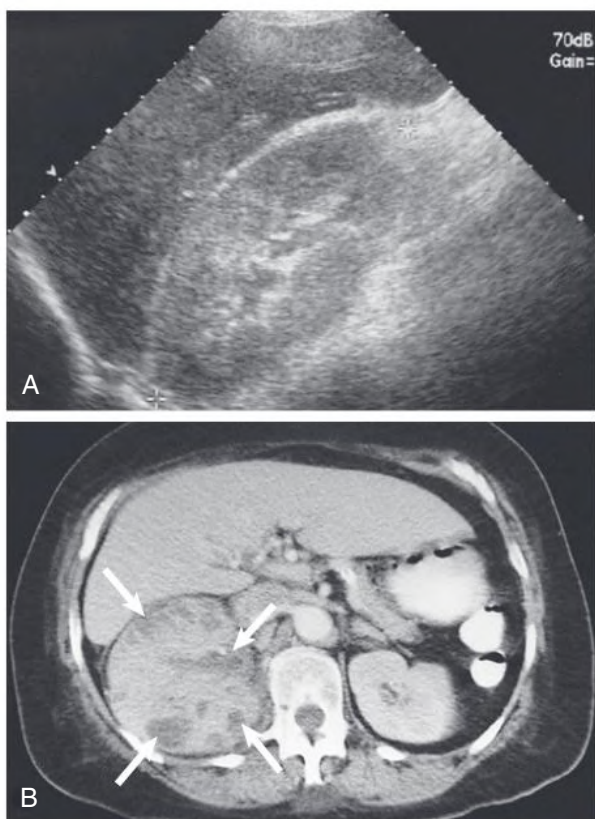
Acute Pyelonephritis. (A) Ultrasound image demonstrates an enlarged echogenic kidney. Bipolar length of kidney is 12.9 cm. (B) Computed tomography scan with contrast enhancement obtained 24 hours later demonstrates multiple nonenhancing abscesses (*arrows*).
